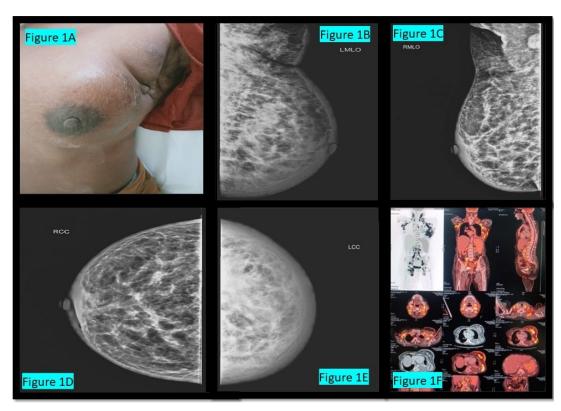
A: Clinicalphotograph of the breast lesion; B: Mammogram picture showing mediolateral oblique view of left breast; C: Mammogram picture showing mediolateral oblique view of right breast; D: Mammogram picture showing craniocaudal view of right breast; F: Picture showing Whole body FDG PET uptake scan at various organs
